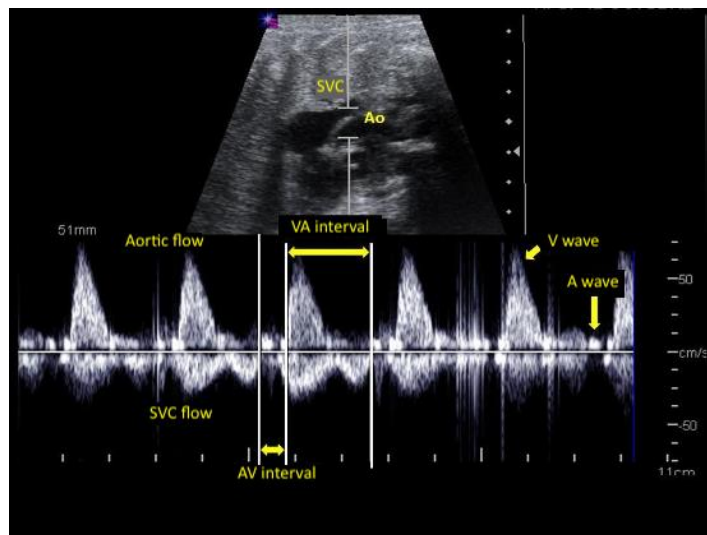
Superior vena cava – ascending aorta pulsed Doppler. The flow corresponding to the A wave of the superior vena cava and the aortic V wave are identified in the upper part of the tracing.
